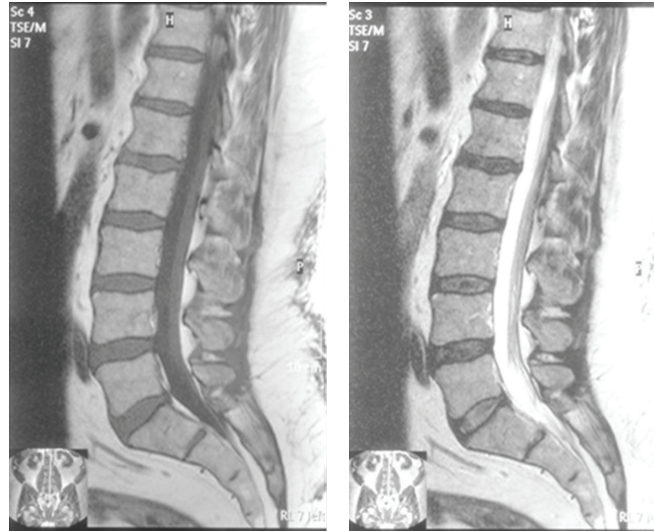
The same patient's T1 and T2 MRI demonstrates decreased disc signal at L4-5.
